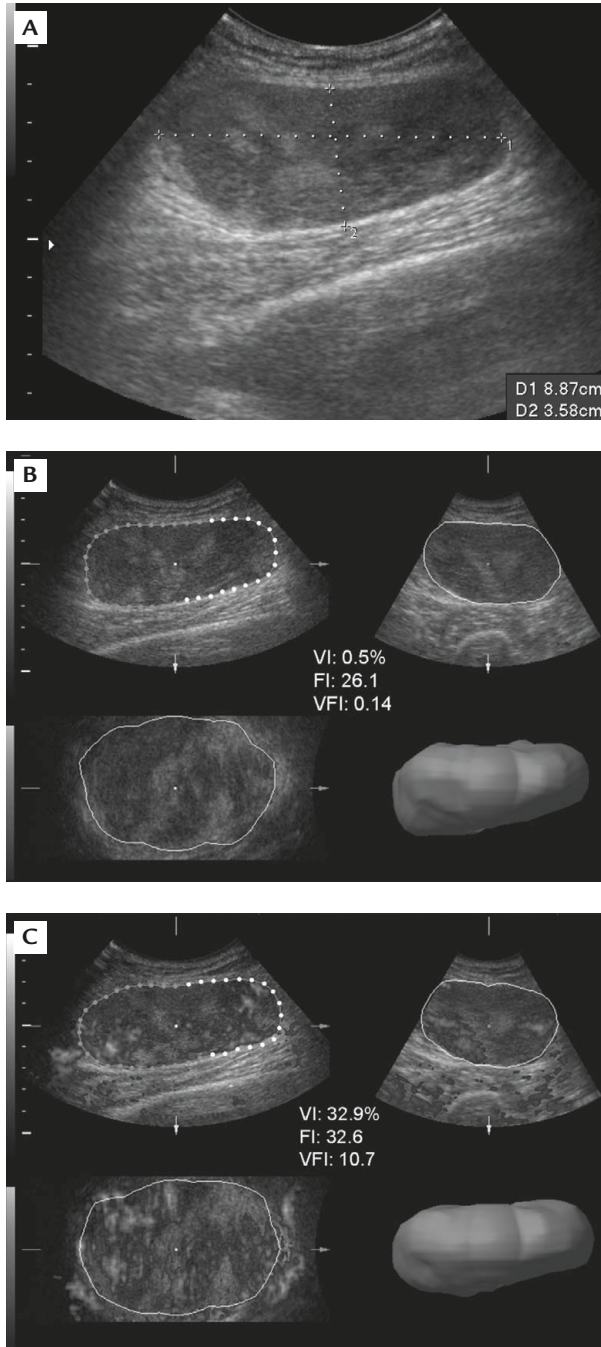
A 43-year-old female patient with the complaint of a palpable mass in her right thigh for 2 years. (A) Grayscale ultrasonography shows an ovoid-shaped heterogeneous echoic nodule (dotted lines) over the right thigh. (B) 3D power Doppler ultrasonography shows only minimal vascularity within the tumor (VI, 0.5%; FI, 26.1; VFI, 0.14). (C) After contrast injection, 3D power Doppler ultrasonography shows marked hypervascularity (VI, 32.9%; FI, 32.6; VFI, 10.7). This tumor was a liposarcoma.
